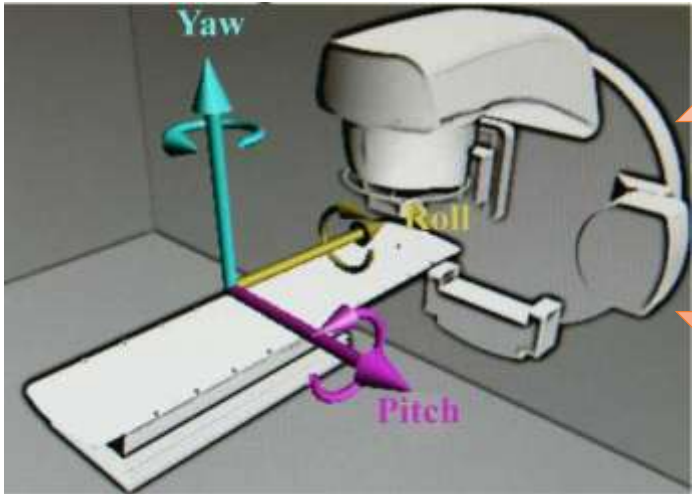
On-board imaging used for IGRT- On-board Cone Beam CT images are registered onto planning CT scan to calculate shifts which are then applied onto the patient's couch to achieve perfect targeting
